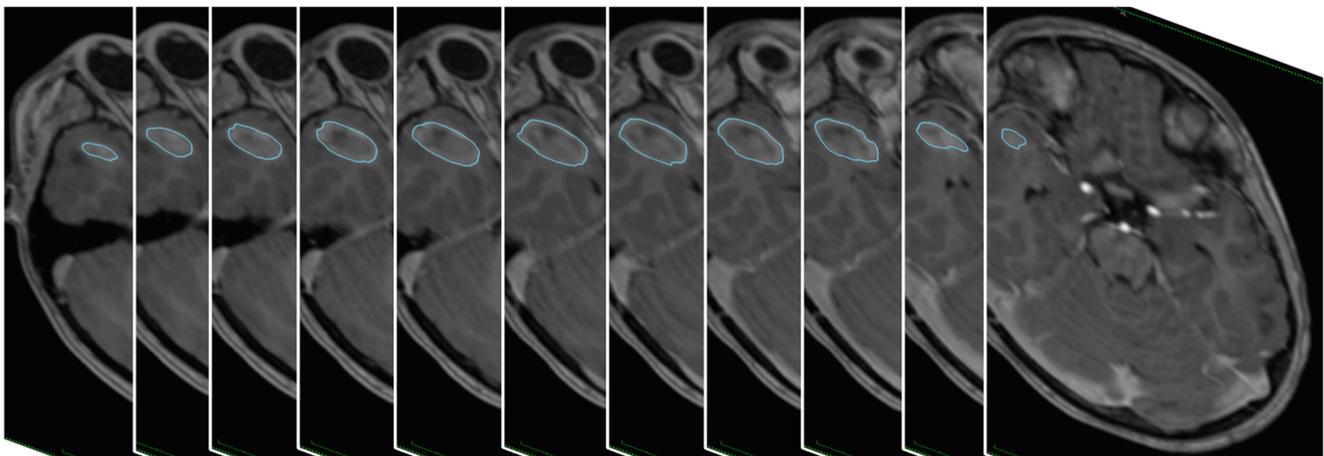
Overlay of post-operative T-1 weighted MRI images in OSiriX demonstrating how post-ablation volumes were calculated using the ROI draw and ROI volume functions
